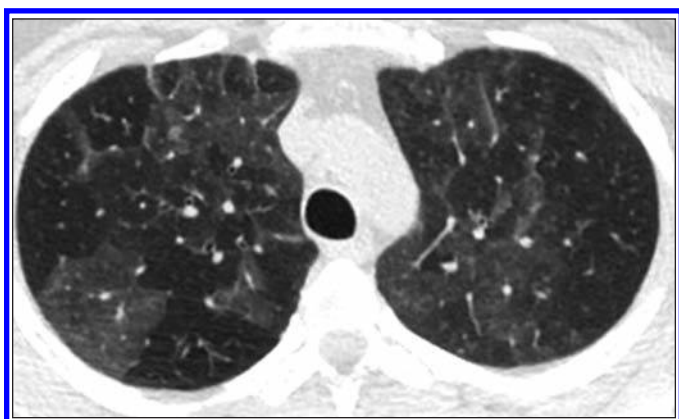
Hypersensitivity pneumonitis (subacute stage). Transverse CT image of chest shows diffuse bilateral ground-glass opacities that cause geographic pattern of mosaic attenuation without architectural distortion, predominantly involving upper lobes.
